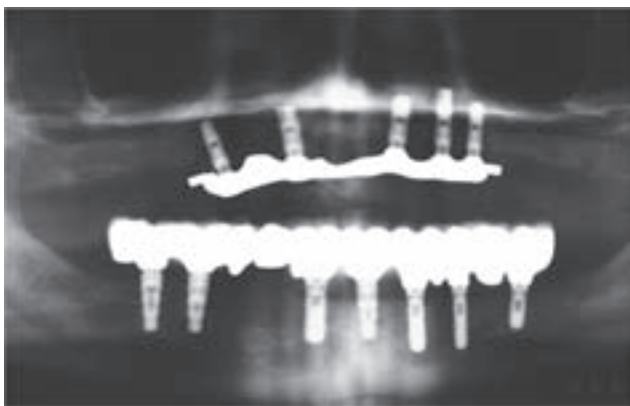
Panoramic radiograph of fixed and removable implant-supported prosthesis.
